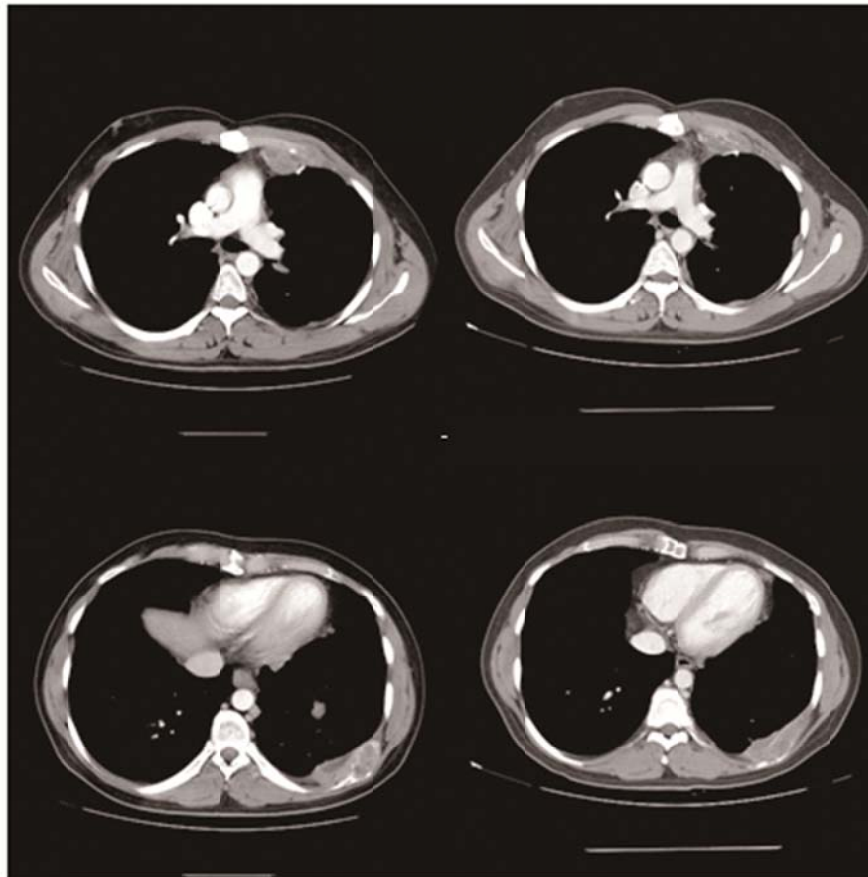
Computed tomography of chest demonstrating anterior mediastinal and left chest wall mass in the beginning of treatment and seven months later. Anterior mediastinal tumor measured initially (left upper frame) 6.5 by 3.5 cm, it decreased to 5.8 by 2.5 cm (right upper frame). Left chest wall mass improved from 8.2 by 3 cm (left lower frame) to 7.7 cm by 2.2 cm to (right lower frame). This improvement was associated with resolution of chest wall pain.
